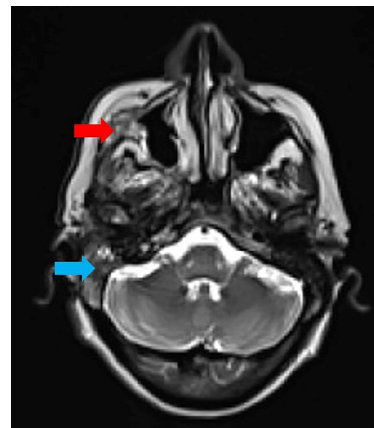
Post-chemotherapy MRI. The red arrow shows the remnant of a maxillary lesion, and the blue arrow shows the remnant of a temporal lesion.
